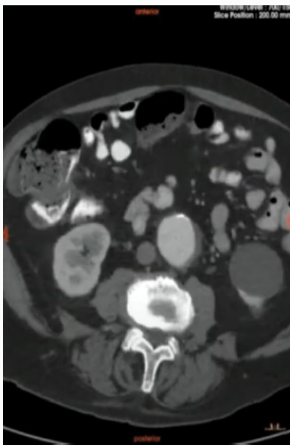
Pre-OP Axial CT.
